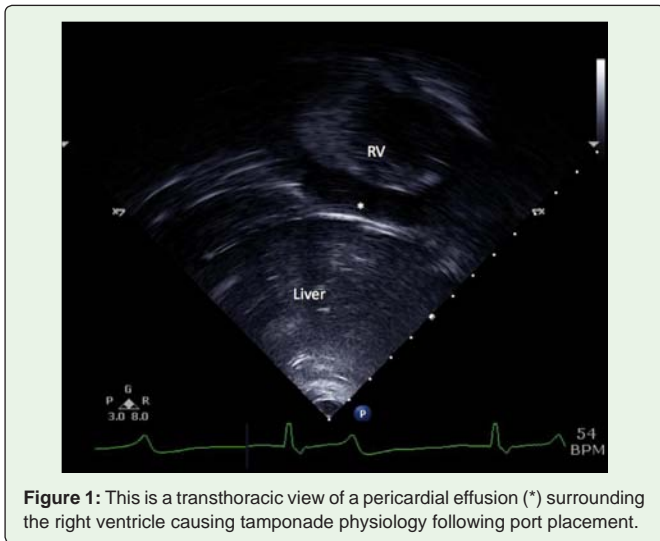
This is a transthoracic view of a pericardial effusion (*) surrounding the right ventricle causing tamponade physiology following port placement.
